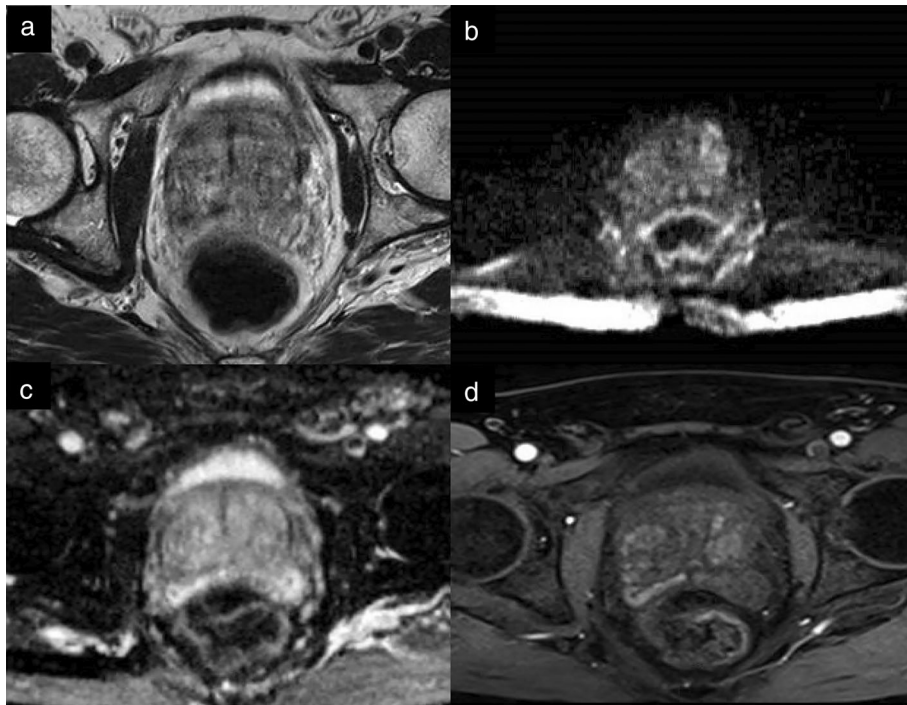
Axial T2-weighted imaging (a), high b value (1400 seconds/mm²) (b), ADC map (c), and DCE acquisition (d) of a study that was given a PI-QUAL score of 2, as only DCE sequences are of adequate diagnostic quality (artifacts from motion and rectal air hamper T2-WI and DWI).
